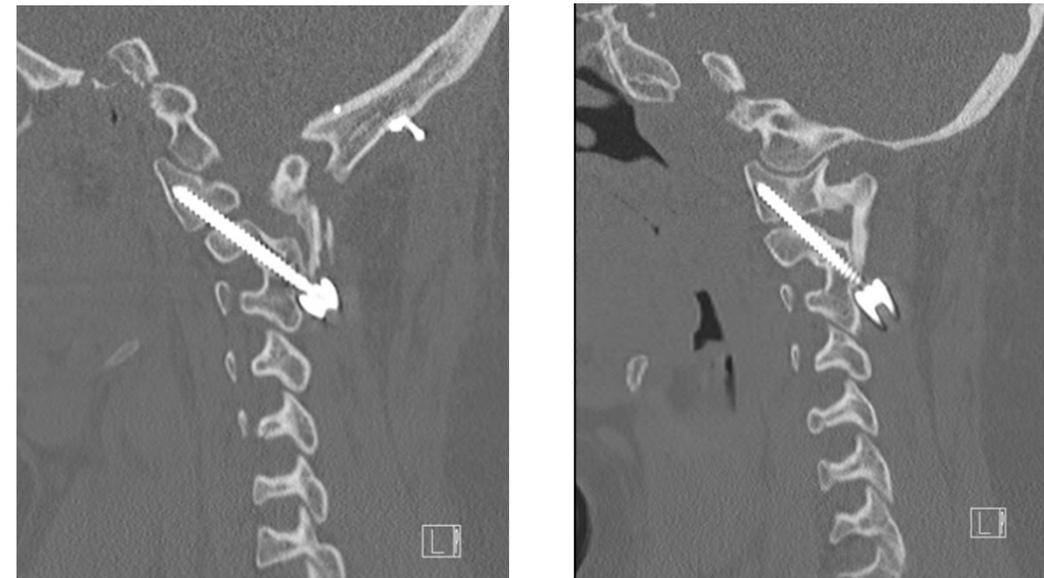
Postoperative CT scan demonstrating accurate C1-2 transarticular screw placement with evidence of posterior bony growth
